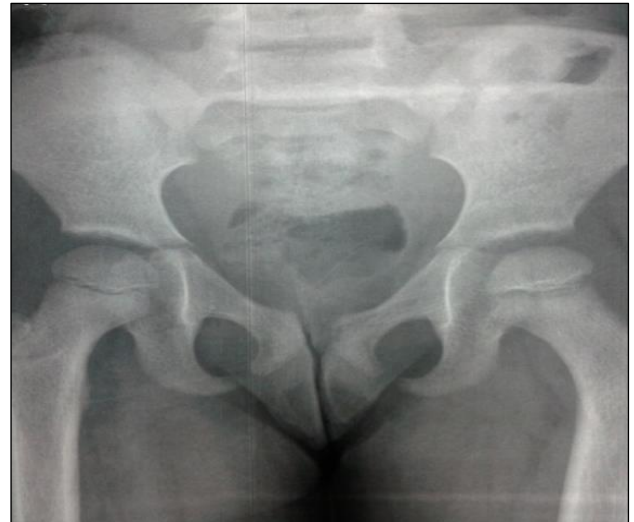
Post reduction X-ray of the hip.
